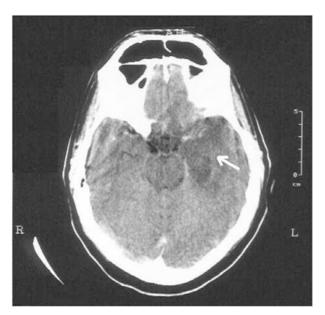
CT scan showing low attenuation in the left temporal lobe.
